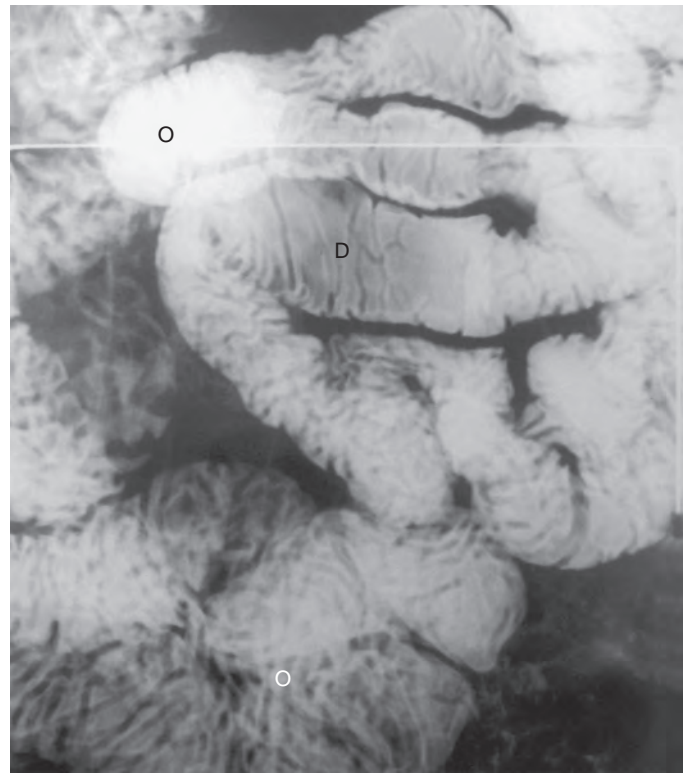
Normal small bowel follow-through. Spot radiograph with compression shows the distal jejunum. When the loops are well distended (D) and separated from each other, an image from a small bowel follow-through is comparable to that from enteroclysis. When loops are overlapping (black O), however, the density of the barium may obscure anatomic detail. When loops are overlapping and partially collapsed, the overlapping folds may form a feathery pattern (white O).
